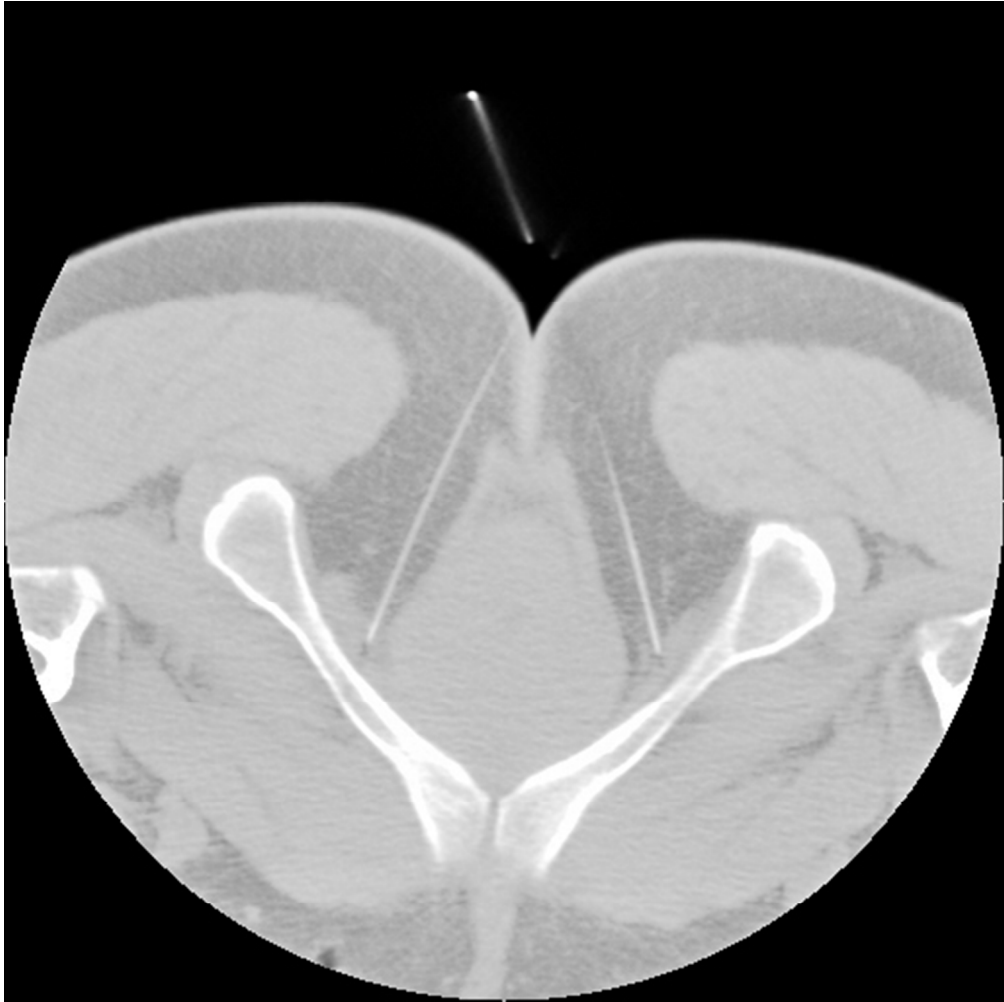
Transverse computed tomography (CT) image of the coccygeal apex
